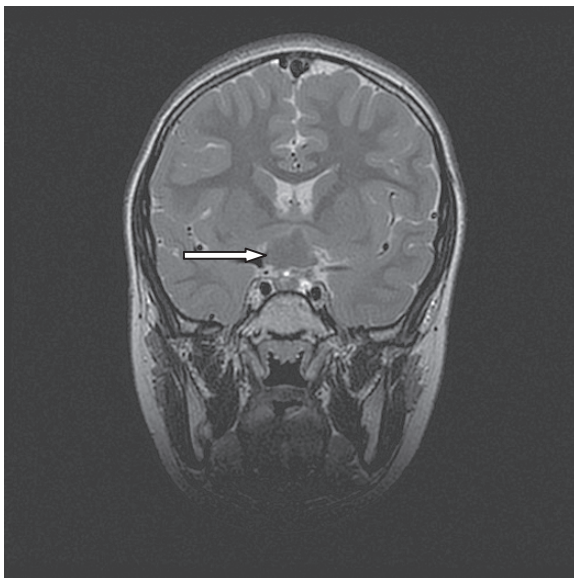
Coronal view of T2-weighted magnetic-resonance scan of a $2.1 \times 2.3 \times 1.8$ cm mass centered in the hypothalamus
